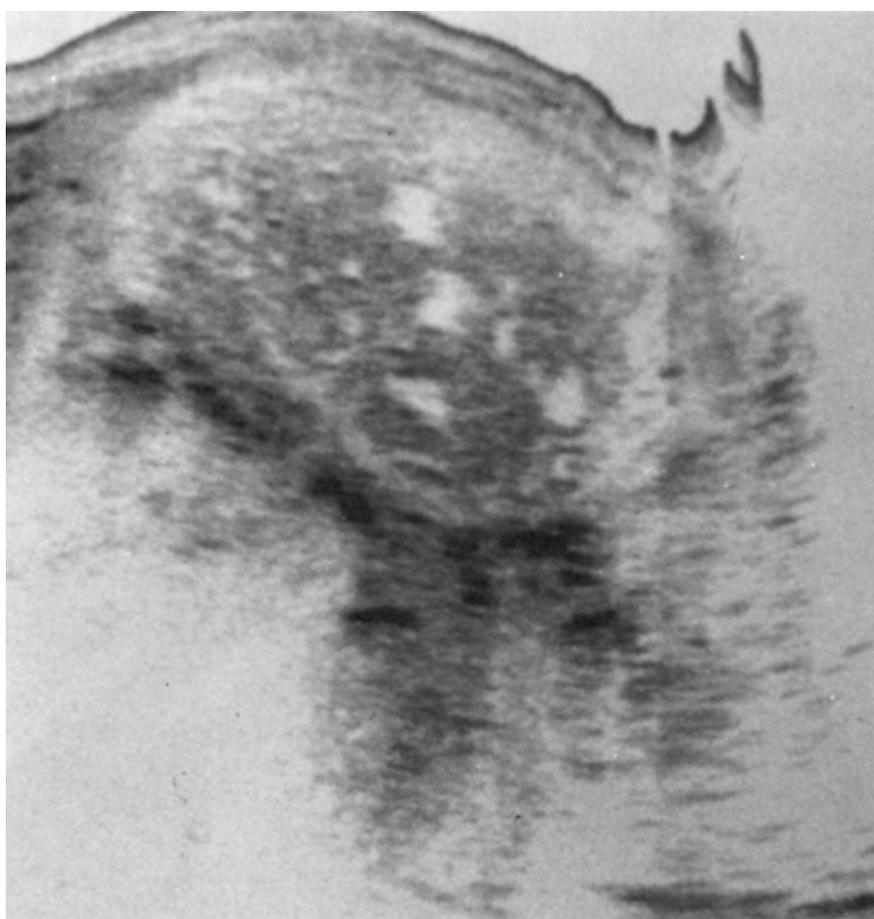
A longitudinal ultrasound reveals a hydatidiform mole. The mixed echoic pattern is caused by hydropic villi and focal intrauterine hemorrhage.
